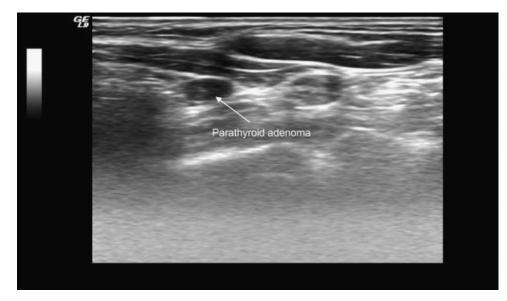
Ultrasound investigation: hypoechoic tissue suggestive of parathyroid adenoma.
